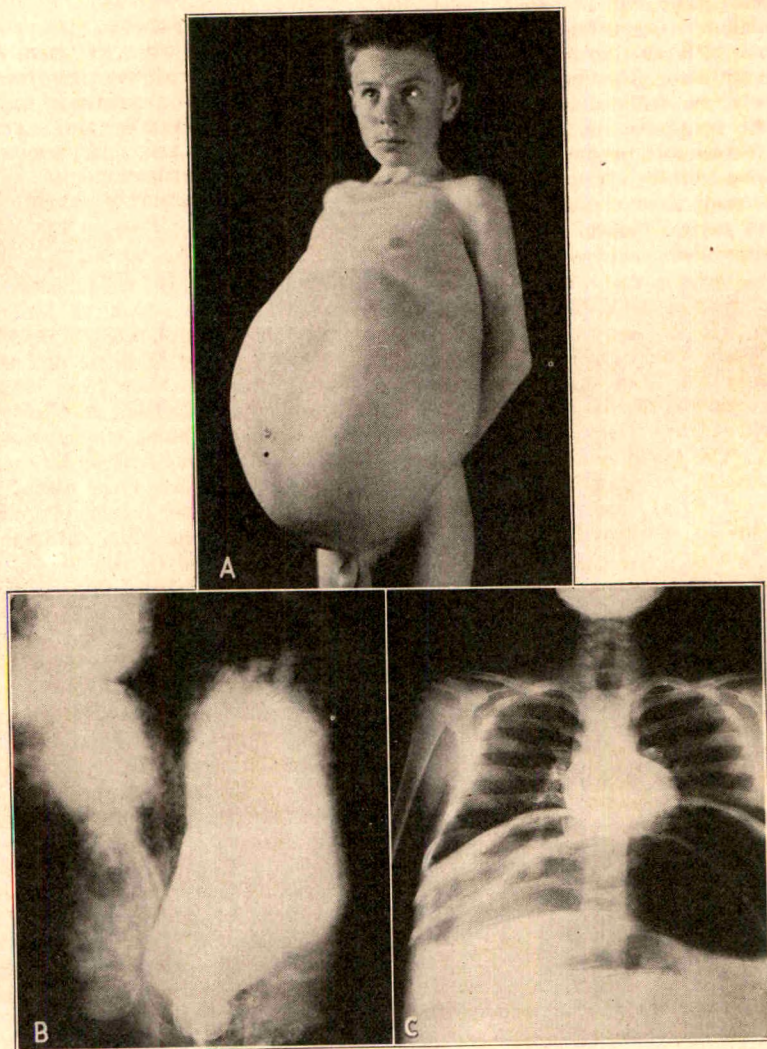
(case 18).—A, photograph of a 15 year old patient with megacolon, showing the abdominal distention, which had progressed from the time of birth. The colon ruptured spontaneously two years later, and the patient died. The normal rectum and normal lower segment of sigmoid colon of this patient resisted evacuation efforts. Colon resection and iliosigmoidostomy were anatomically possible. B, roentgenogram of the same patient, showing the normal rectum and a normal lower segment of sigmoid colon. The enormously impacted loops of the proximal segments of the colon overlie the normal portion of the sigmoid flexure. C, roentgenogram of the chest showing the upward displacement of the diaphragm and the compression of the lungs in the same patient. Pulmonary and cardiac symptoms occurred during episodes of severe distention.
